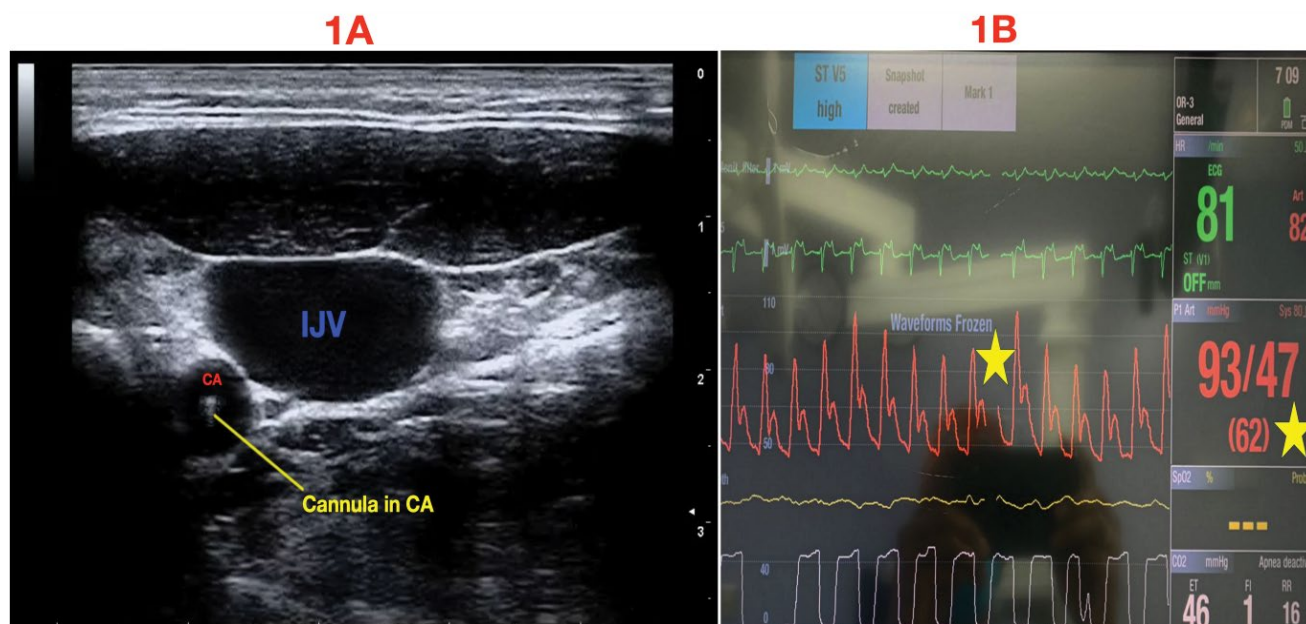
(A) Ultrasound image showing cannula in the left carotid artery; (B) Multipara monitor showing invasive carotid artery pressure tracing and carotid arterial blood pressure (yellow star).
